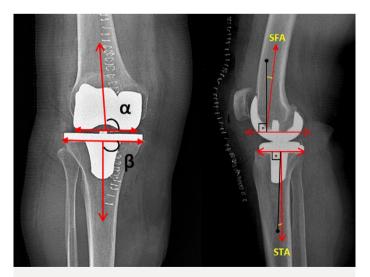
Measurements of the frontal and sagittal femoral and tibial component angles (α , β , SFA, and STA) on short knee radiographs.
